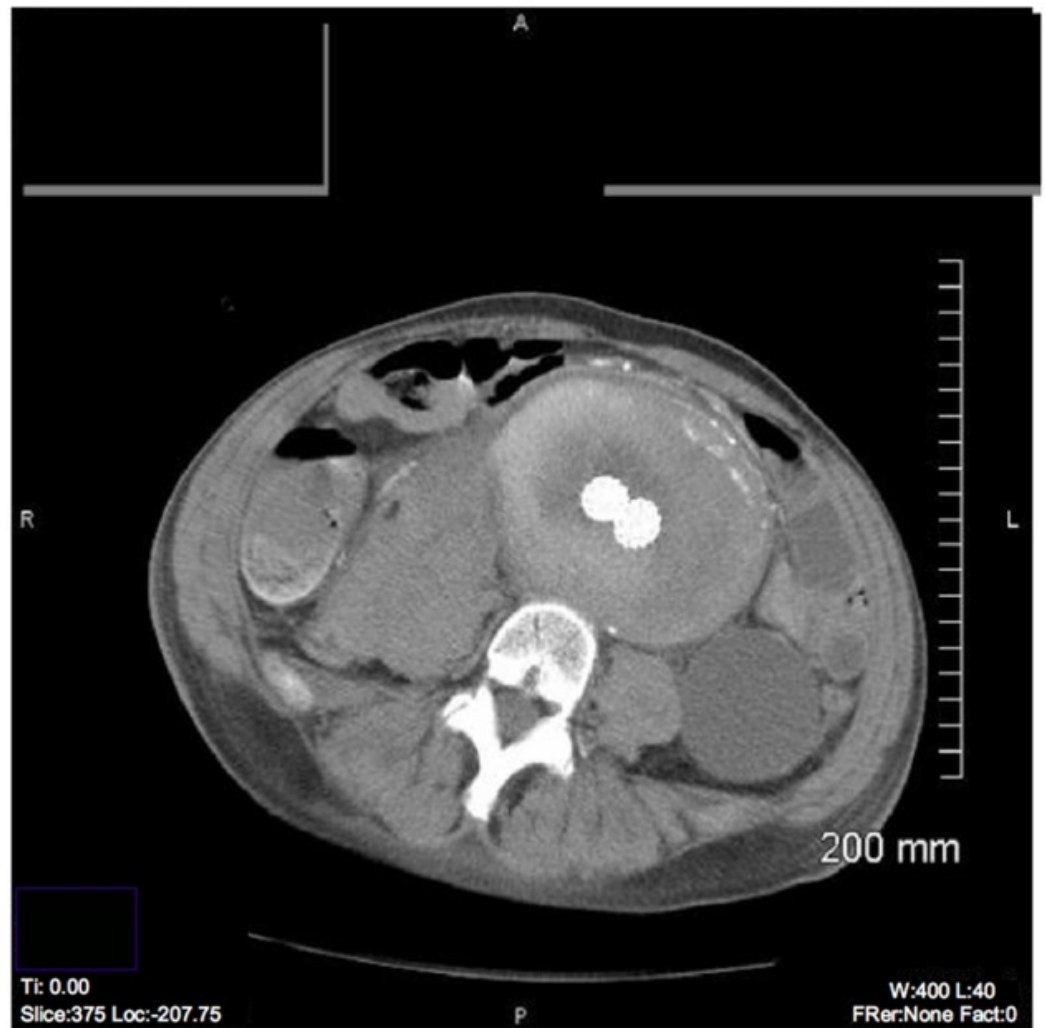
Post-operative CT showing endovascular stent graft
